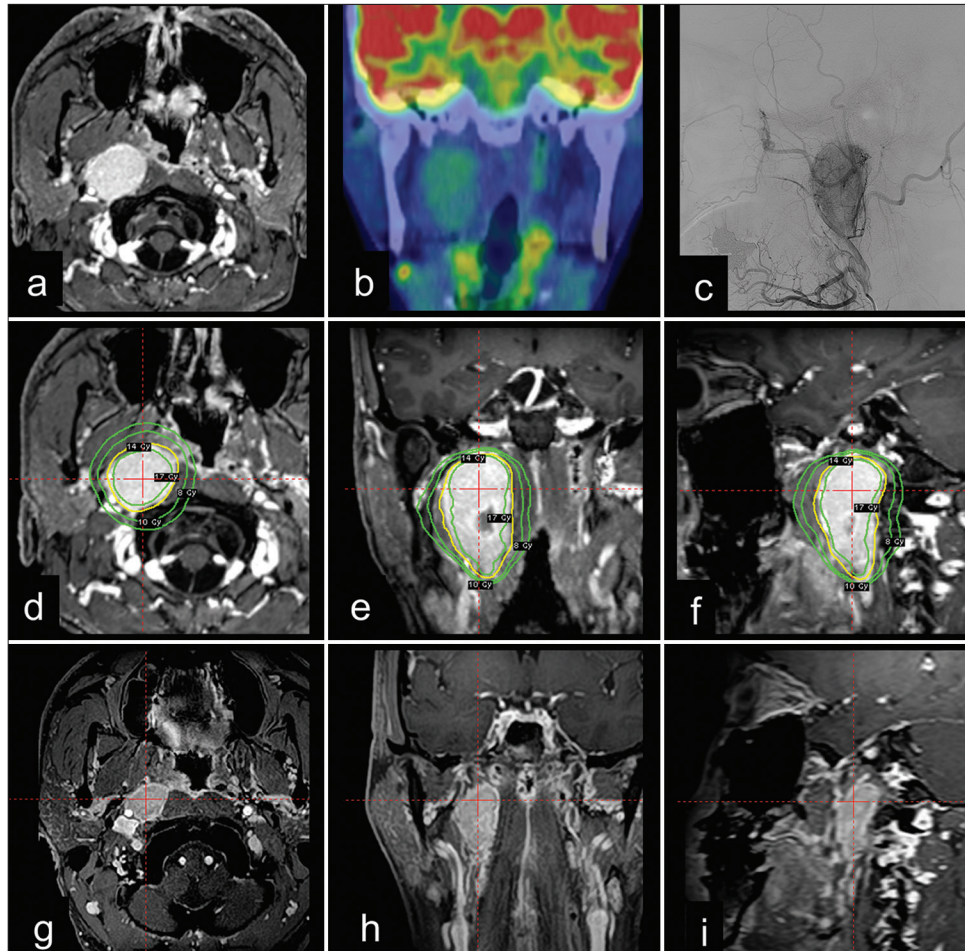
Vagal paraganglioma incidentally detected in a 47-year-old man. (a) Gadolinium-enhanced, T1-weighted magnetic resonance imaging (MRI) showing a well-enhanced tumor in the parapharyngeal space. (b) Positron emission tomography revealed increased fluorodeoxyglucose uptake within the lesion, with no evidence of metastasis to the other location. (c) Digital subtraction angiography showing the hypervascularity of the tumor, primarily supplied by the ascending pharyngeal artery. (d-f) Stereotactic radiosurgery (SRS) with Gamma Knife using mask fixation was performed, and radiosurgical planning images are shown in the axial, coronal, and sagittal planes. The yellow line indicates the 45% isodose line for the prescribed treatment dose of 14 Gy, and the green lines indicate the doses of 8, 10, and 17 Gy. (g-i) The patient's clinical course was uneventful, and MRI revealed significant tumor shrinkage with a 70% decrease in volume 25 months after SRS.
